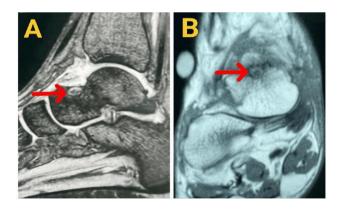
MRI of the right ankle with T2-weighted (A) sagittal and (B) T1 weighted axial: it shows a well-defined lesion with a narrow zone of transition with surrounding reactive bone showing marrow edema.
